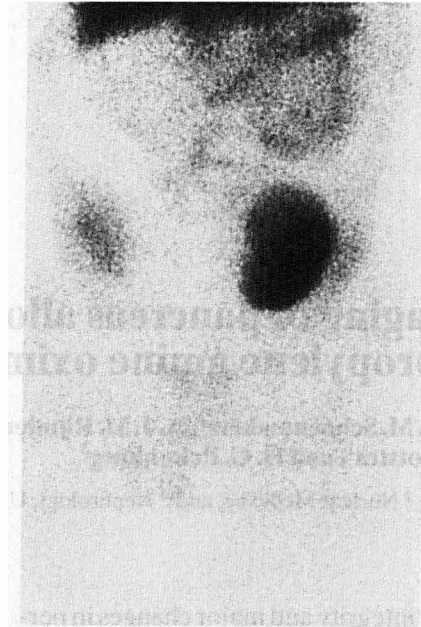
Typical scintigraphic image of pancreas graft thrombosis. This patient received a combined pancreas/kidney transplantation. However, no activity is seen in the lower right abdomen and in the area of the aortal bifurcation, where the pancreas was transplanted. The simultaneously transplanted kidney has a good perfusion
